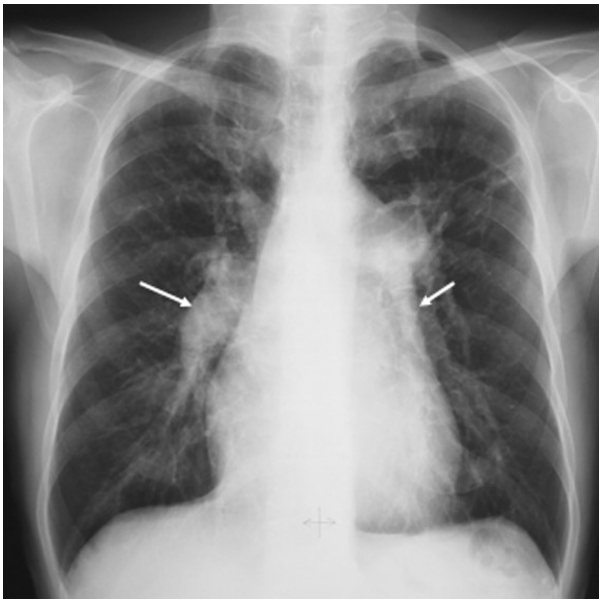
Frontal chest radiograph with enlargement of the right descending pulmonary artery (RDPA) and left descending pulmonary artery (LDPA) in a patient with pulmonary hypertension (arrows). RPDA >16 mm and LDPA >18 mm are considered abnormal and predictive of the presence of pulmonary hypertension. Note the additional presence of a focal infiltration in the left axillar region.
